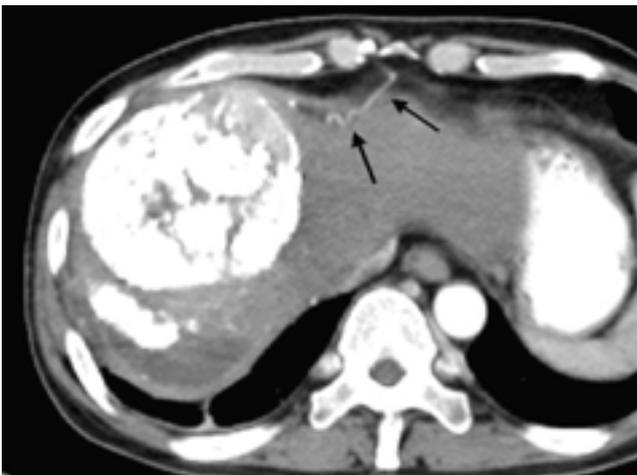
Enhanced axial CT image (arterial phase) shows an enhanced recurrent HCC in the right lobe of the liver adjacent to the diaphragm and tortuous enlarged vascular structure (arrows), which is considered to be parasitic supply from the right internal mammary artery.
